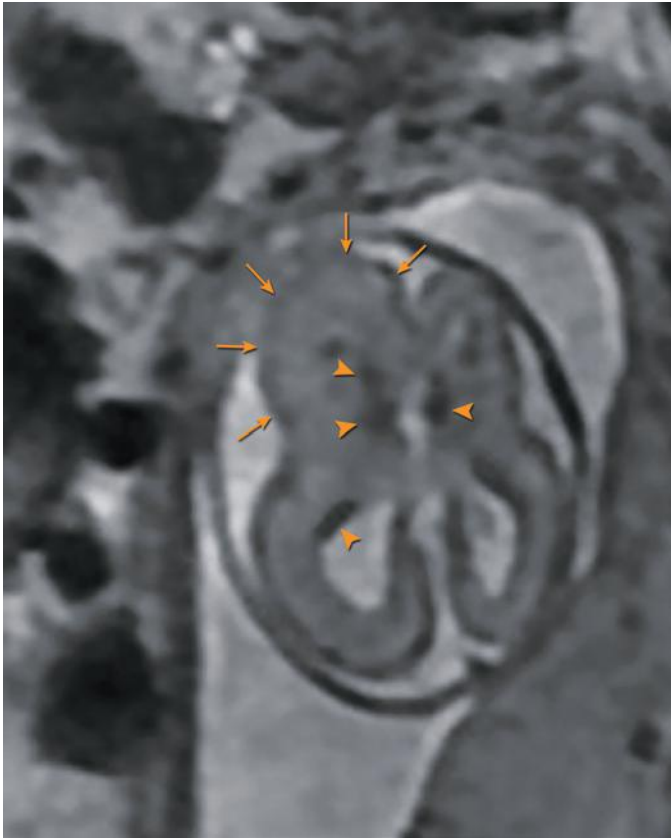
Hemimegalencephaly at 19.5 weeks' gestation in a patient referred for ventriculomegaly. Axial T2-weighted imaging demonstrates asymmetric cerebral hemispheres, with increased cortical thickness (*arrows*) and pachygyria involving the right cerebral hemisphere. The right lateral ventricle is mildly dilated and there are multiple subependymal and cortical low signal intensity foci (*arrowheads*).
